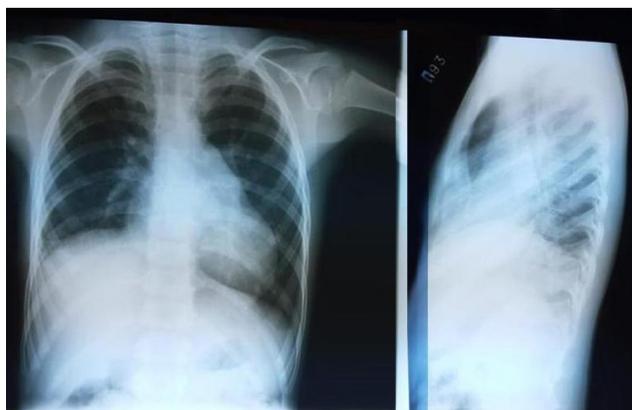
Chest x-ray in two projections (8 months after surgery). There were no infiltrative and volumetric pathological formations; there was no reaction from the pleura
